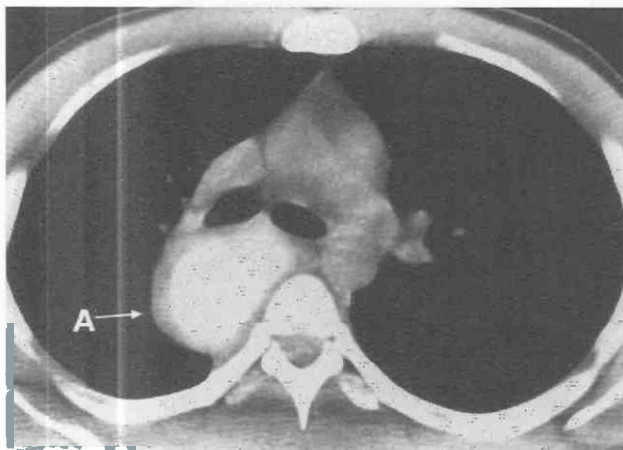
Achalasia. CT shows dilated esophagus (A) in a patient with achalasia. The esophagus displaces the azygos vein to the right.
